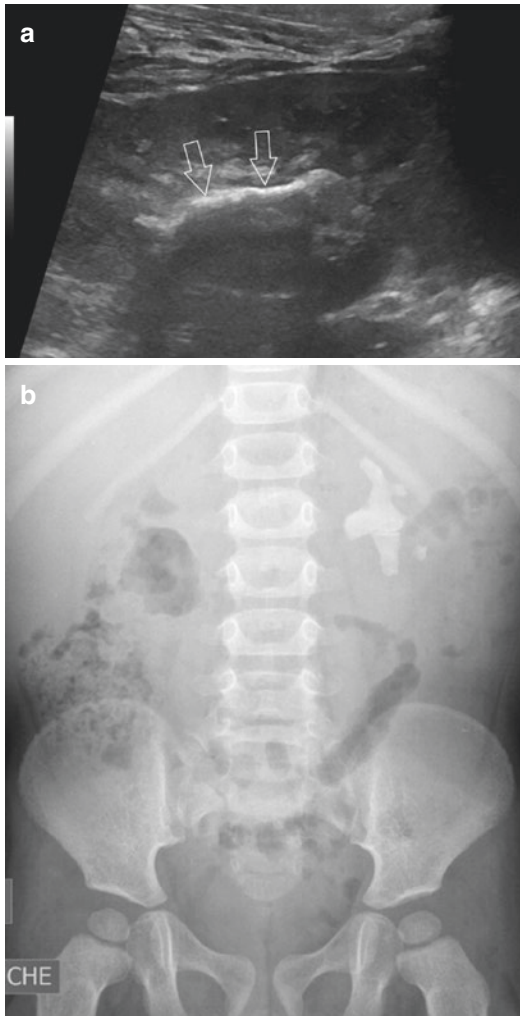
Staghorn lithiasis—case of congenital cystinuria. (a) Sagittal scan of the left kidney. The staghorn urolithiasis appears as a long thick line with limited shadowing (arrows). (b) Plain radiograph of the abdomen demonstrating the calcified staghorn urolithiasis
